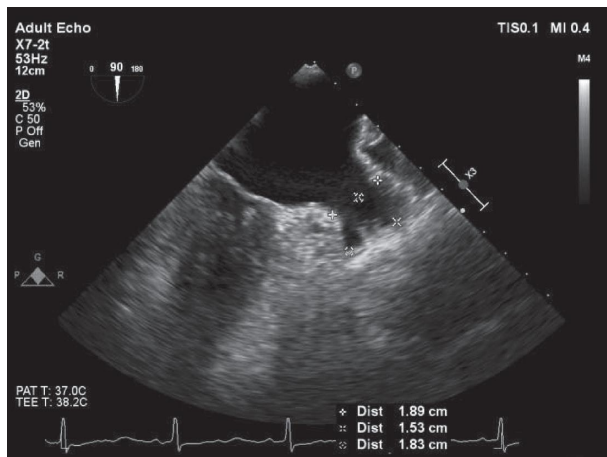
Example of transesophageal echocardiography.
